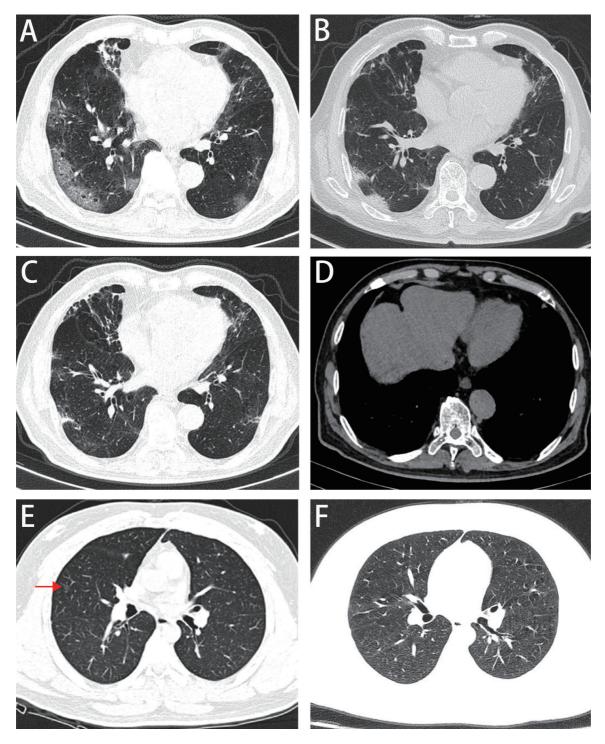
Lung and abdomen CT scans of case 1 and case 2. (A–D) Case 1: Lung CT scans on February 14 (A), February 22 (B), and February 28 (C), and abdomen CT scan on February 14 (D). (E–F) Case 2: Lung CT scans on February 13 (E) and March 2 (F). CT, computed tomography.
